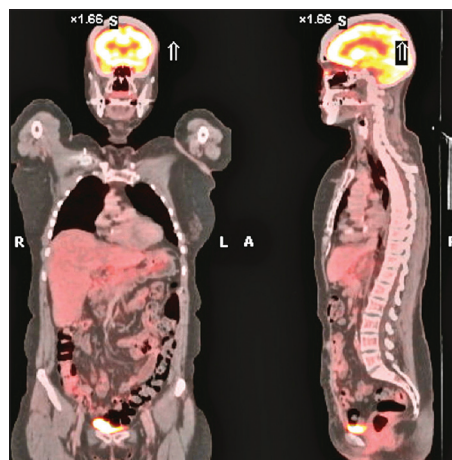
Positron emission tomography-computed tomography aspect
